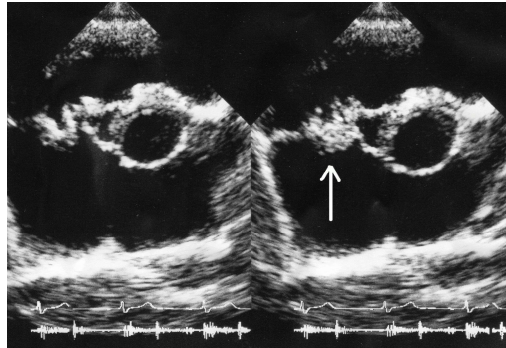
Vegetation on tricuspid valve visualised on echocardiography. Arrow denotes the vegetation.
